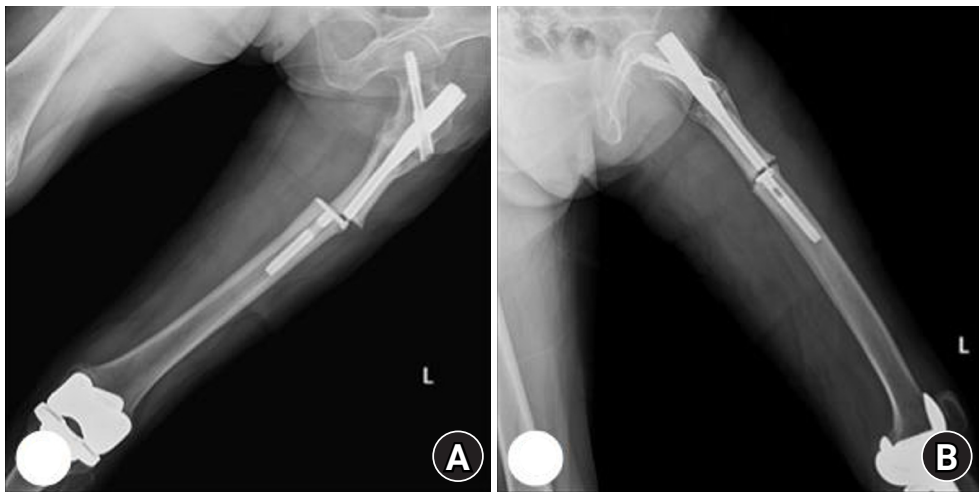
Radiographs of the same patient with a femoral shaft fracture and implant failure. (A) Anteroposterior view. (B) Lateral view.
